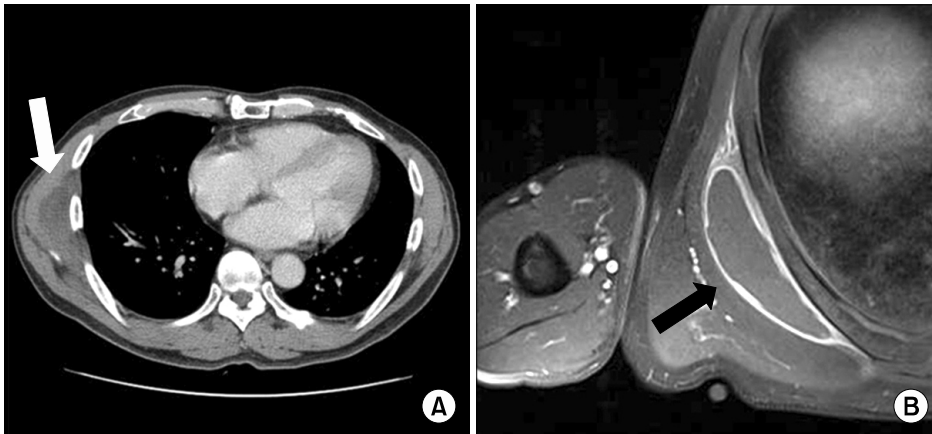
(A) Chest computed tomography shows a heterogeneous cystic mass measuring approximately 8×2.5 cm on the right chest wall lateral aspect inferior latissimus muscle (white arrow). (B) A magnetic resonance axial T1-weighted image revealed a well-defined cystic mass located in the right subscapular region (black arrow).
